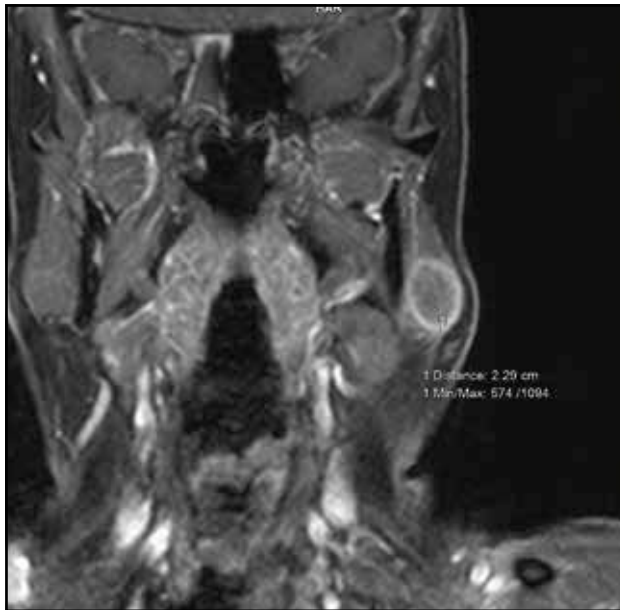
Neck MRI, coronal slice. Left parotid carcinoma interpreted by the radiologist as “benign cystic tumor” – encapsulated, well defined tumor, with cystic aspect. Intraoperatively, we identified a mass tumor with no cystic aspect, which included and infiltrated the left parotid gland. Thus, a more extensive surgical technique was needed.
